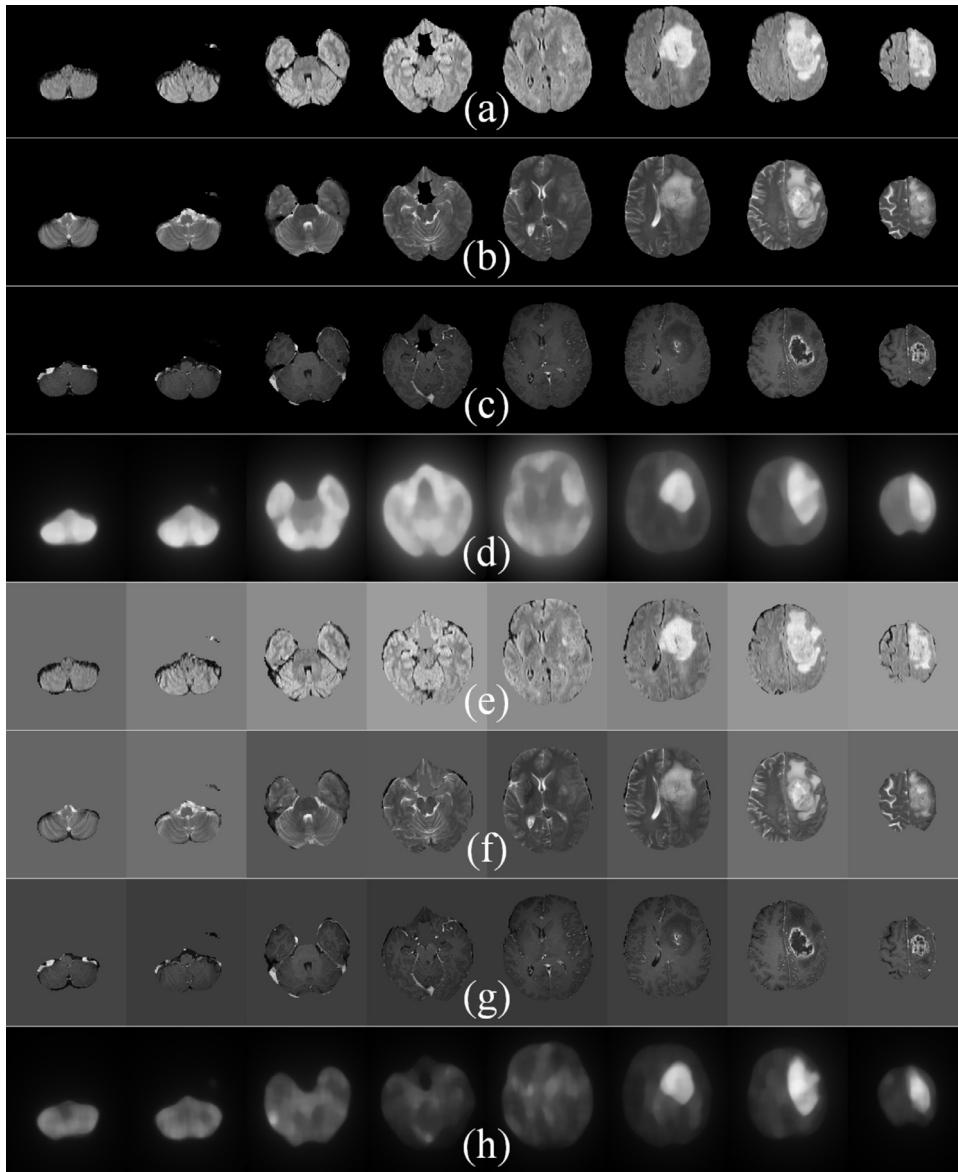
2D saliency maps corresponding to the 2D MR slices of a High-grade glioma patient from BRATS data base (Patient ID = brats_2013_pat0011_1). MR slice numbers: 13, 19, 35, 46, 67, 81, 100, 121 (left to right) by (a) *FLAIR*, (b) *T2*, and (c) *T1C* sequences. (d) Saliency maps generated from the original slices. Modified MR slices, with mean intensity values replacing background pixels, for (e) *FLAIR*, (f) *T2*, and (g) *T1C* sequences. (h) Saliency maps from the modified MR image slices, where ROI is clearly visible/salient in last three slices.
